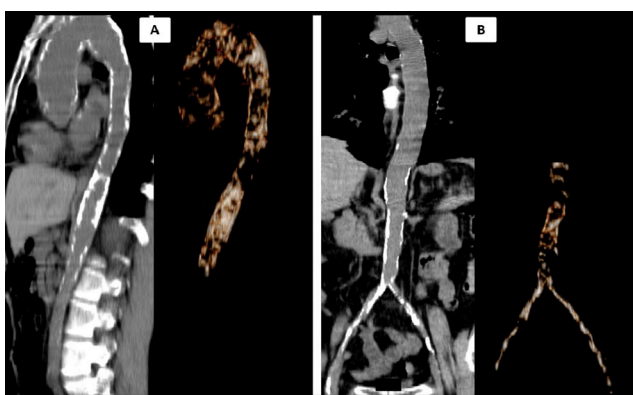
Multiplanar reconstructions on the sagittal (A) and coronal (B) plane, and volume rendering reconstructions of the CT images of representative PET-CT scan of an LVV patient (A) and a non-LVV patient (B). Calcification burden in the thoracic aorta was much higher in the patient with LVV. LVV, large vessel vasculitis; PET-CT, positron emission tomography-CT.
